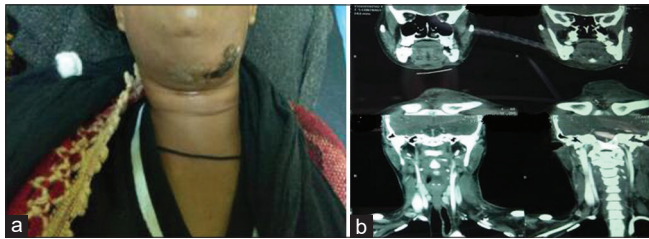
(a) Pre-operative picture, (b) Computed tomography scan images after tooth removal
